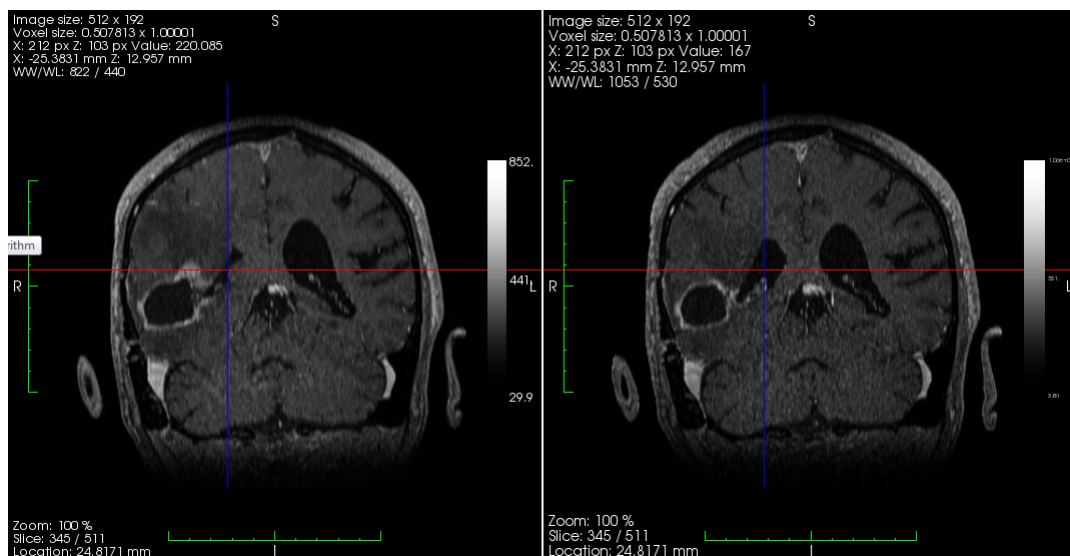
A sample sagittal slice from baseline (on the right) and follow-up (on the left) MRI.
